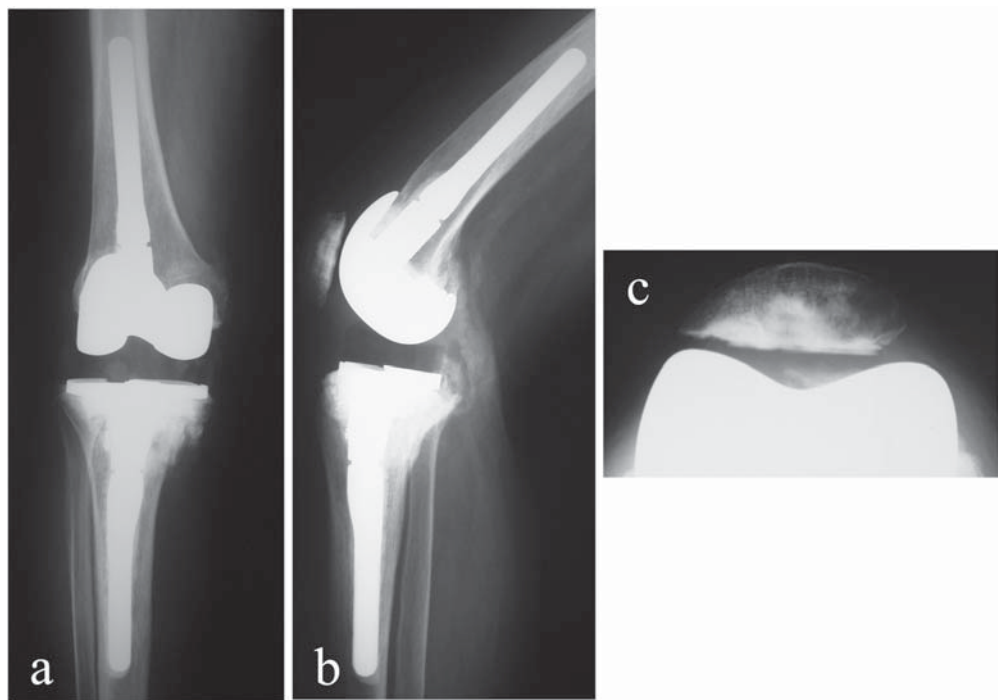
Follow-up radiographs (a anterior–posterior view, b lateral view, c skyline view) showing bone integration at the medial tibial condyle, and no radiolucent line around the new components or the cement
